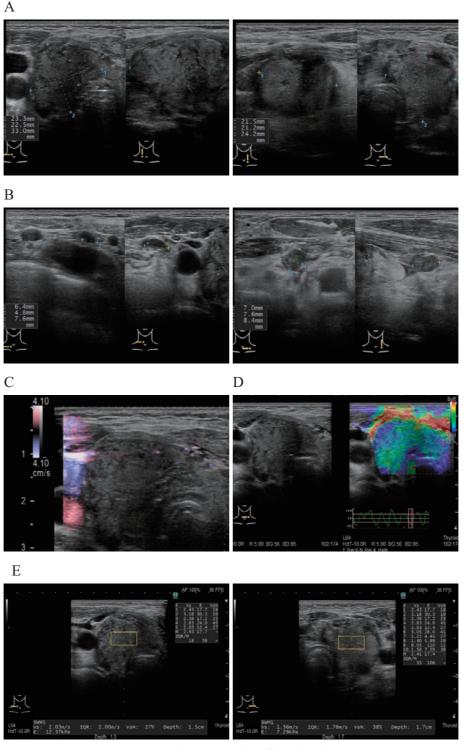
Ultrasonography of the thyroid.
